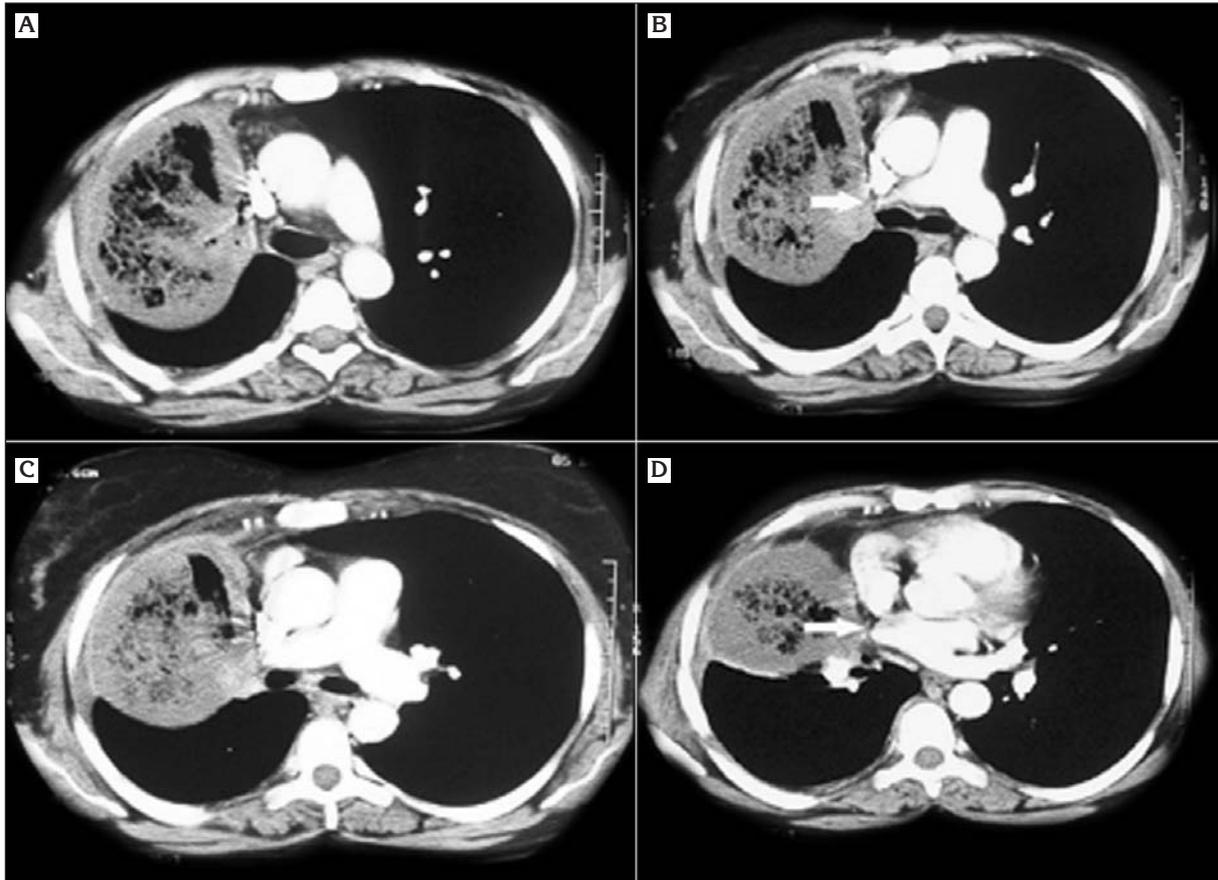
Axial CT angiography images. A: The infarcted right upper lobe is seen as a low density swollen lobe containing gas densities. B: The right upper lobe artery is narrowed (arrow). C: Both the right and left main pulmonary arteries appear normal. D: Axial contrast-enhanced CT section at a more caudal level shows ligated right superior pulmonary vein (arrow).
